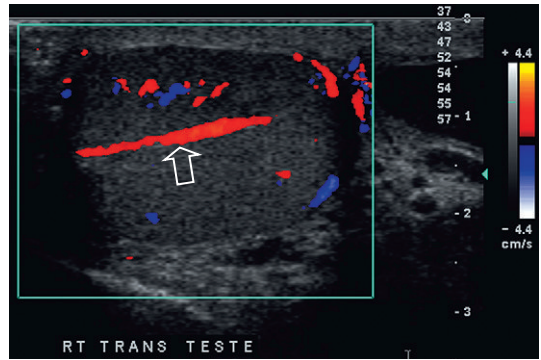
Longitudinal colour Doppler image of a testicle. A transtesticular artery (arrow) can be seen coursing obliquely through the testicle along the mediastinum. It is a branch of the testicular artery, but is seen in less than half of normal cases.
